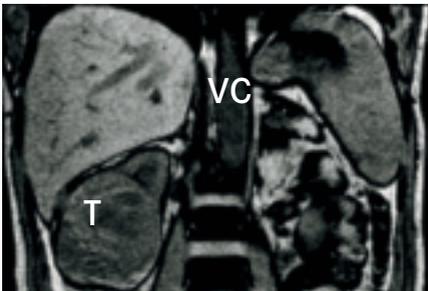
Magnetic resonance image of a renal cell carcinoma (T), with a tumour thrombus in the inferior vena cava (VC).
